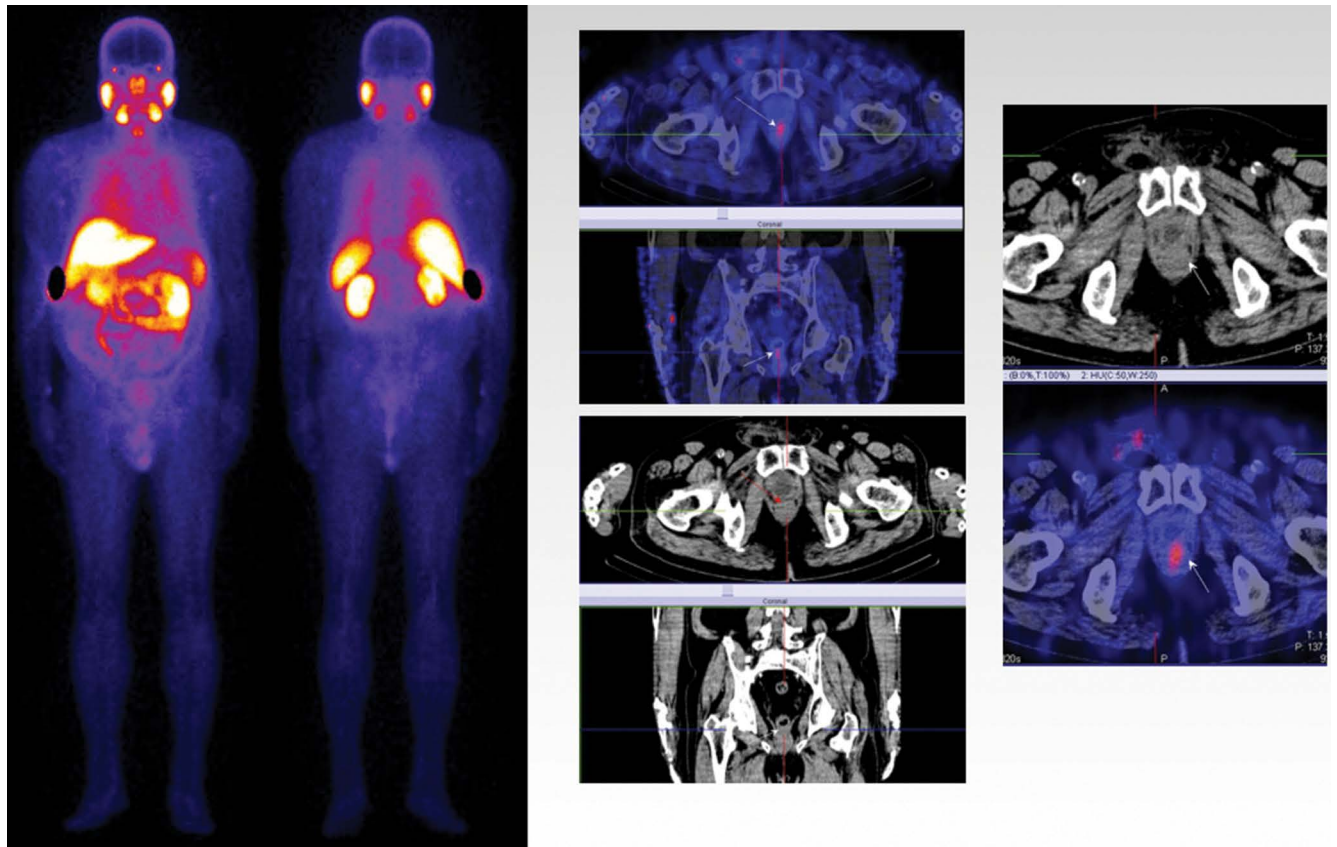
M/70yr with prostate cancer, pT2N0M0, G2, GI = 7 (3 + 4). Radical prostatectomy (2017) and radiotherapy. PSA = 0.24 ng/mL (06/2019). Whole-body scan and target ^{99m}Tc Tc-PSMA-T4 SPECT-CT imaging showed local recurrence in the prostatic bed with intensive tracer uptake. Disease progression
